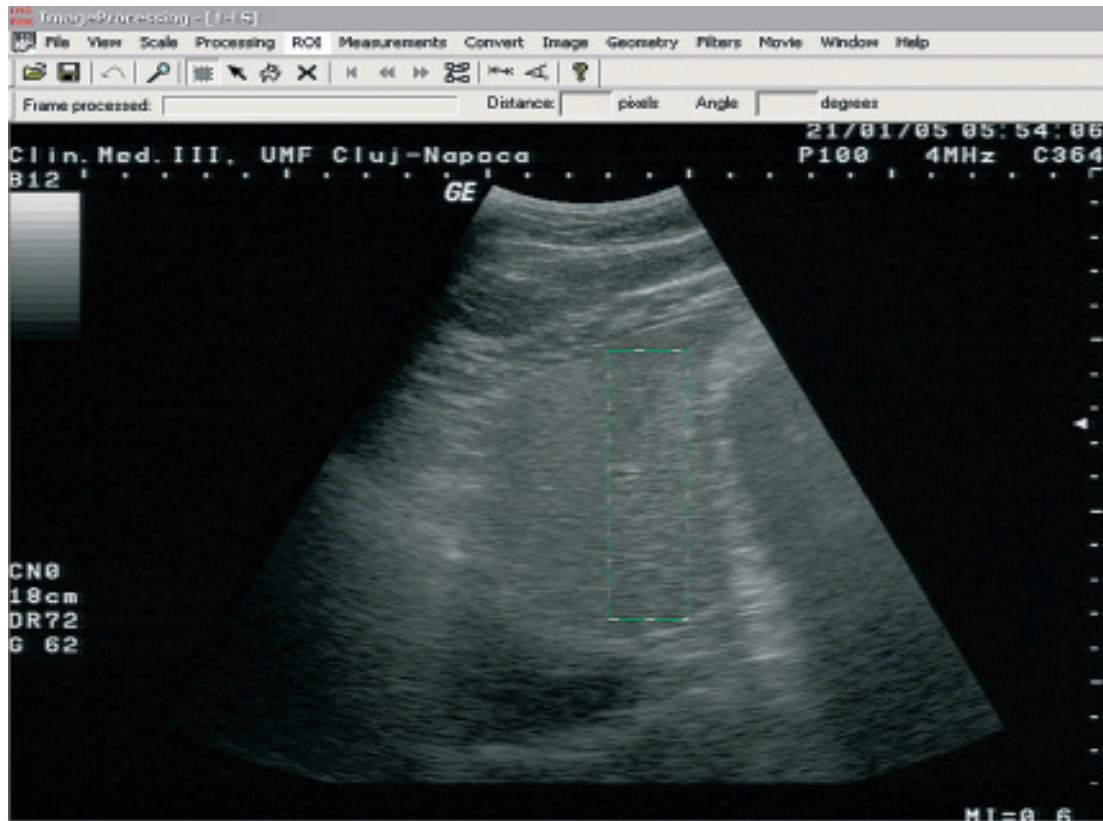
The selection of an interest area on the ultrasonic image for which the grey levels and the different texture parameters shall be calculated.
